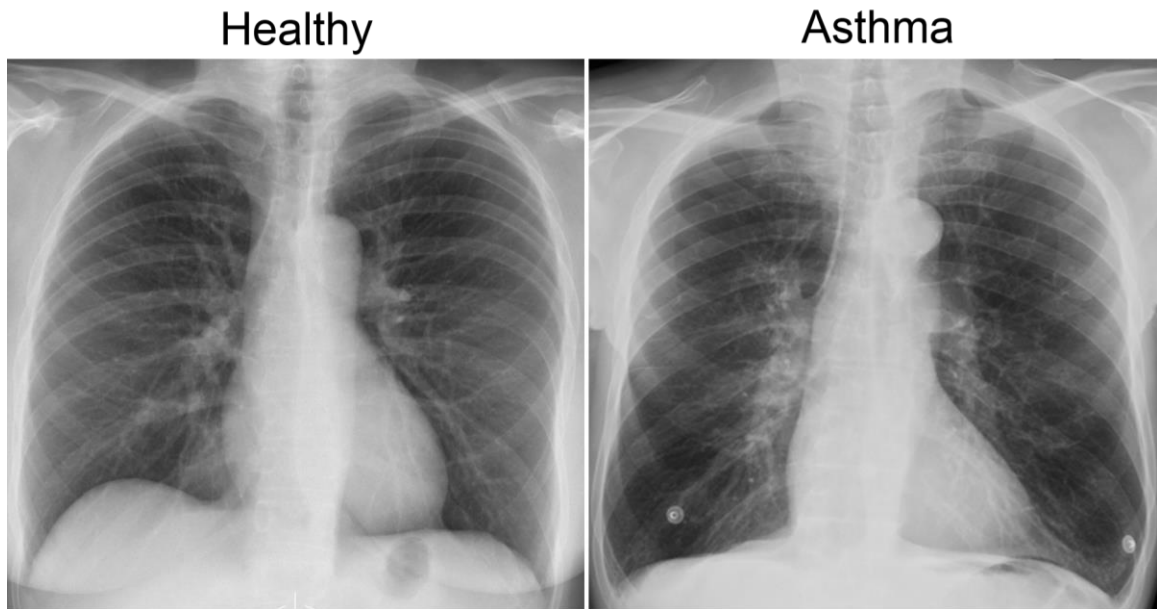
Representative posterior-anterior chest radiograph of a healthy volunteer and an asthmatic subject.
